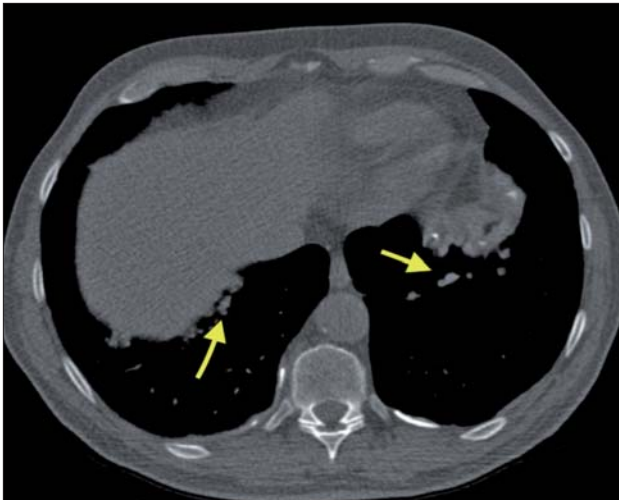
Unenhanced High Resolution CT showing multiple nodular thickening of the diaphragmatic pleura (yellow arrow)
